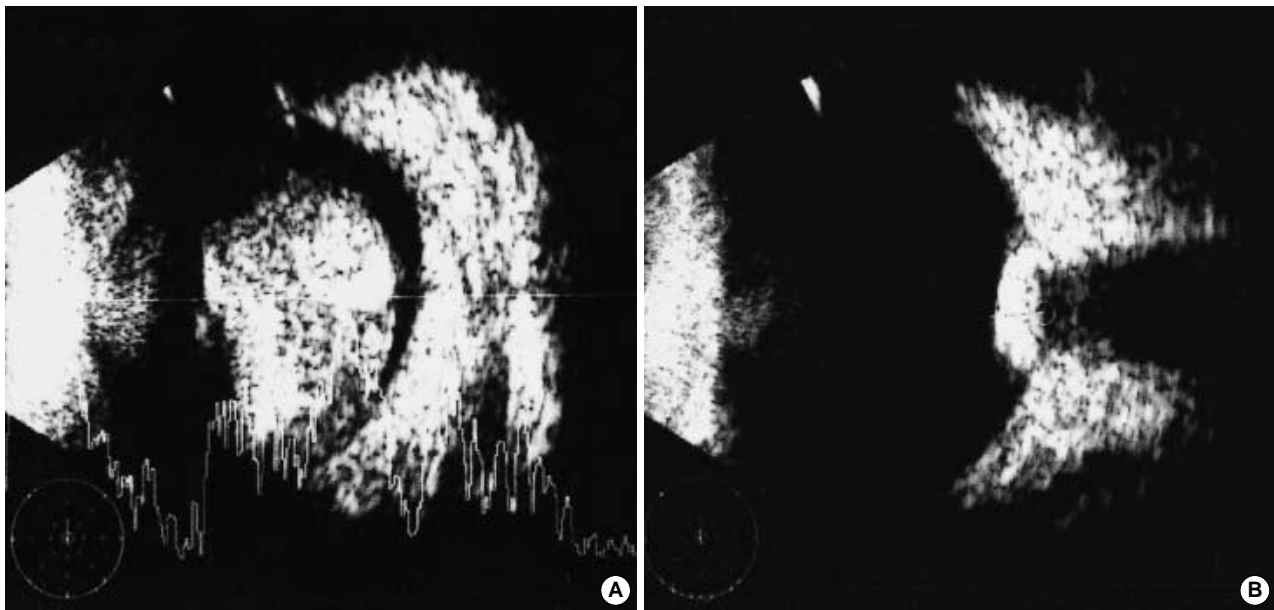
Ultrasonographic finding of the globe in a patient with right intraocular retinoblastoma. Initial large intraocular mass (A) was dramatically reduced in size (B) after 6 cycles of VEC (vincristine, etoposide, and carboplatin) chemotherapy.
